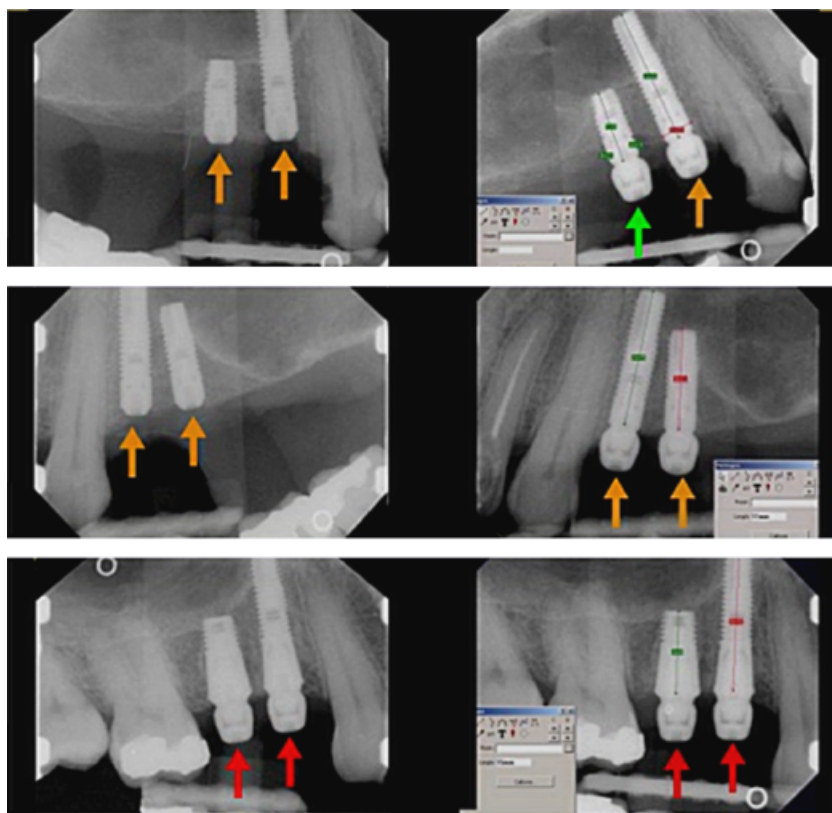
Radiographs taken at implant placement and after abutment connection (2-stage implants), or after three months (1-stage implants). Orange arrow: 2-stage submerged, green arrow: 2-stage exposed, red arrow: 1-stage.
